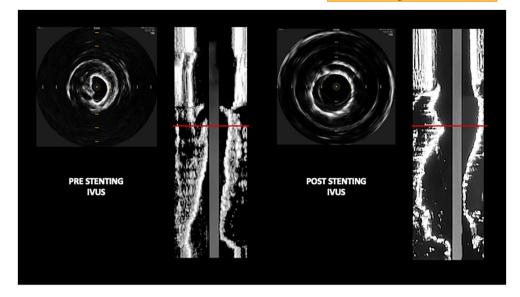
Intravascular ultrasound of outflow graft obstruction before and after endovascular treatment.
